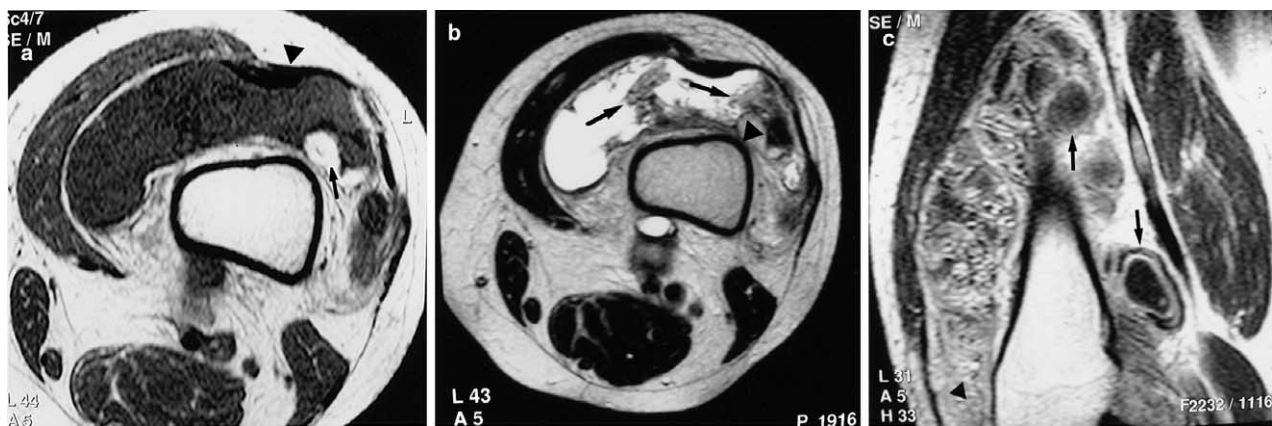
Pigmented villonodular synovitis of the knee: MR imaging 2 years after Fig. 1. (a) Axial T1-weighted Spin Echo image (600/15), shows the intraarticular effusion, fatty tissue of synovial origin (arrow) and a low-signal intensity lesion anteriorly (arrowhead). (b) Axial T2-weighted Fast Spin Echo (6000/95) shows the fatty elements (arrows) and the low-signal intensity PVNS lesions (arrowhead), (c) sagittal contrast enhanced T1-weighted Spin Echo (600/15) image shows the synovial enhancement (arrowhead) along with the non-enhancing intraarticular low-signal intensity PVNS lesions (arrows).
